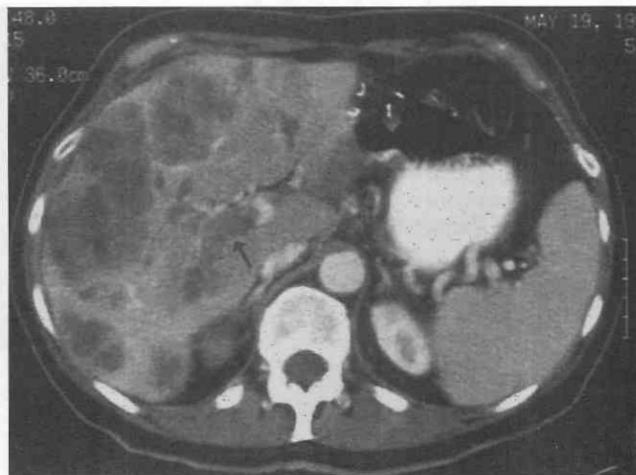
Extensive gastric adenocarcinoma metastases and portal vein thrombosis in a 68-year-old man. Contrast-enhanced CT scan shows multiple low-attenuation masses of the liver with thrombus present in the right portal vein (*arrow*). Surgical clips are present related to previous partial gastrectomy.
